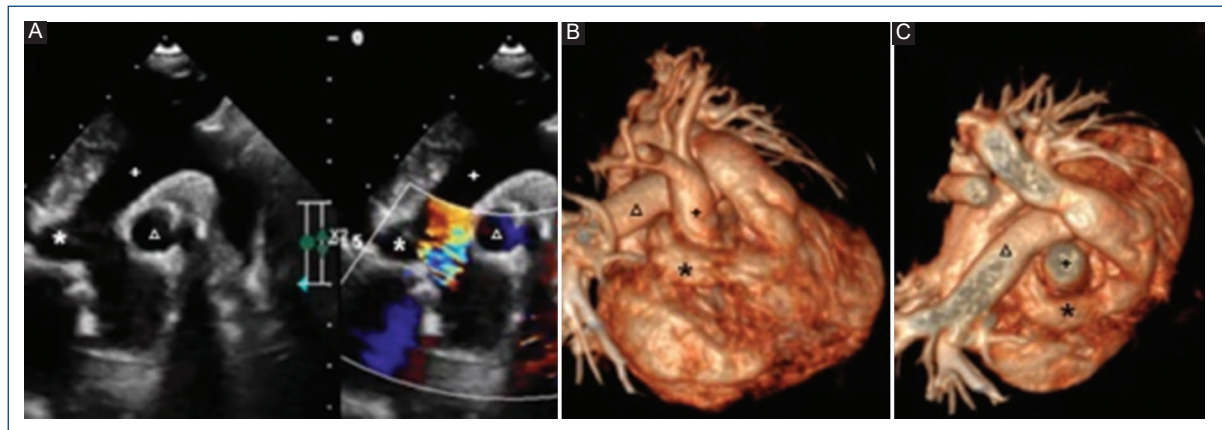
A: transthoracic echocardiogram: circular image adjacent to ascending aorta. B and C: computed tomography angiography: circular and elongated structure in an anterior position and at the right side of the ascending aorta. (*) Left atrial appendage, (+) ascending aorta, (Δ) right pulmonary artery.
